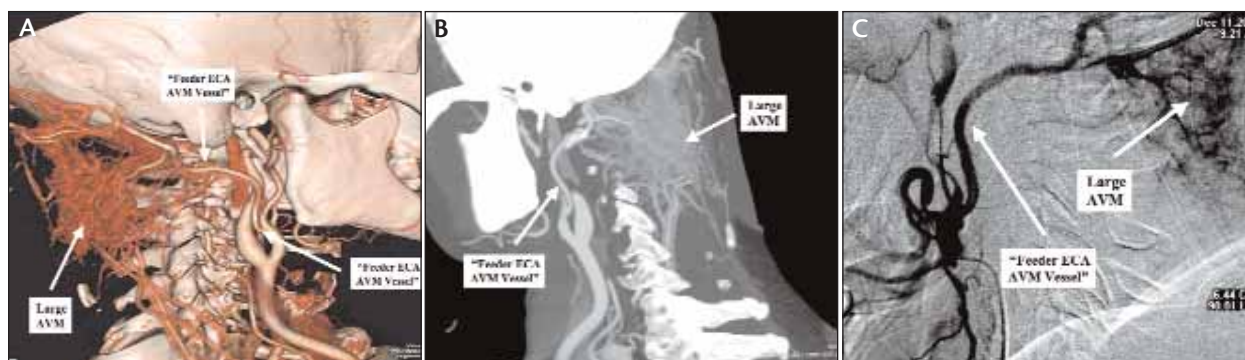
CTA images of a large AVM identifying all anatomic and vascular detail including a large feeder vessel from the external carotid artery (A,B). The large feeder vessel was identified during angiography/digital subtraction angiography and coiled, facilitating definitive surgical resection (C).
